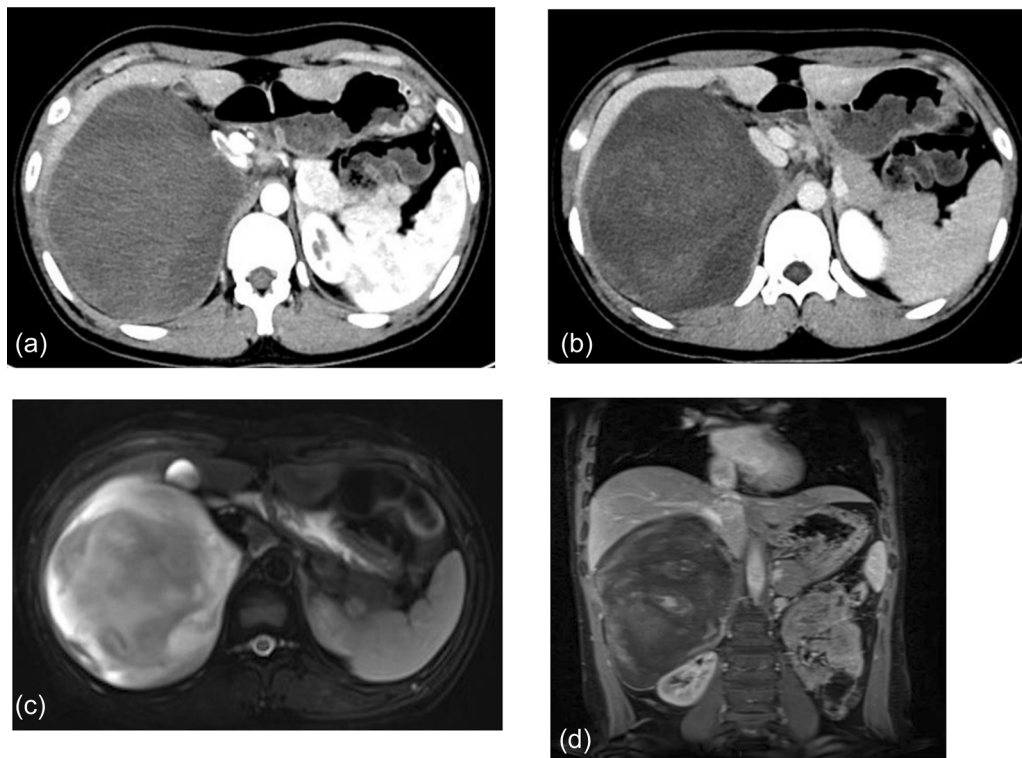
CT and MRI images of the patient. (a) Contrast-enhanced CT shows that the hypodense mass has no enhancement in the arterial phase; (b) CT scan reveals the mass showing inhomogeneous flocculent enhancement in the venous phase; (c) MRI shows a heterogeneous high T2 signal; and (d) Contrast-enhanced MRI shows mild enhancement in the delayed phase and anterior displacement of the inferior vena cava and portal vein. CT, computed tomography; MRI, magnetic resonance imaging.
